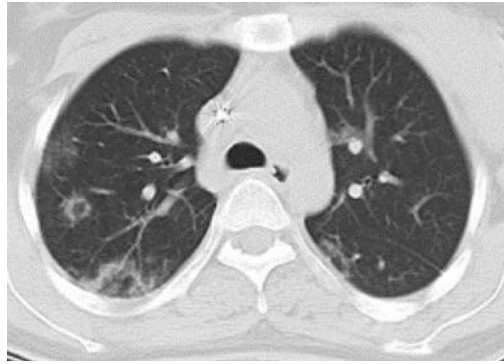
Thin section CT shows multifocal peripheral GGO, with reverse halo appearance
